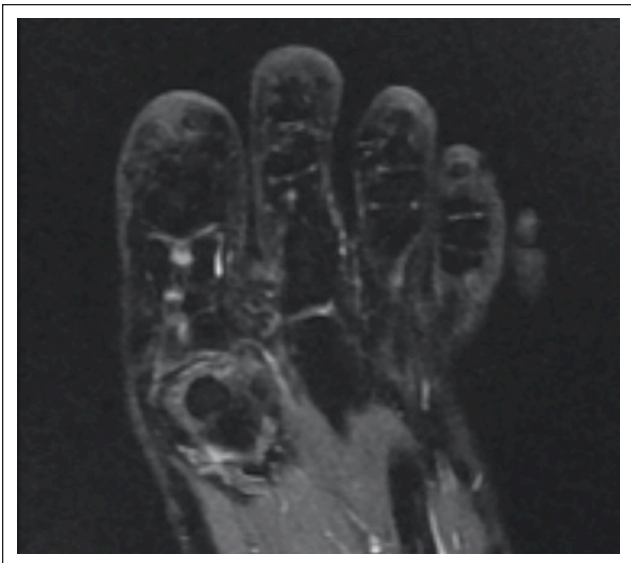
A 44-year-old female underwent an initial cheilectomy and Moberg (CM) revised with a polyvinyl alcohol (PVA) implant 21 months after the initial procedure. Magnetic resonance imaging at 8 months following the PVA implant procedure shows persistent edema surrounding the implant.
